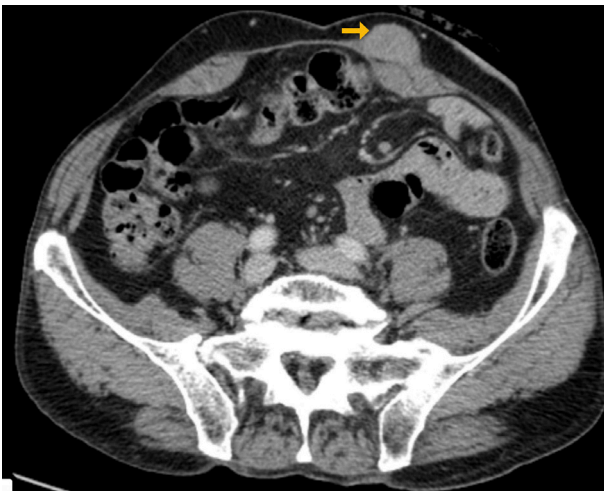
Abdominal wall fibromatosis in a 64-year-old female. Axial CT enhanced image showing a well defined nodular enhancing lesion (arrow) in the left rectus abdominis muscle.
